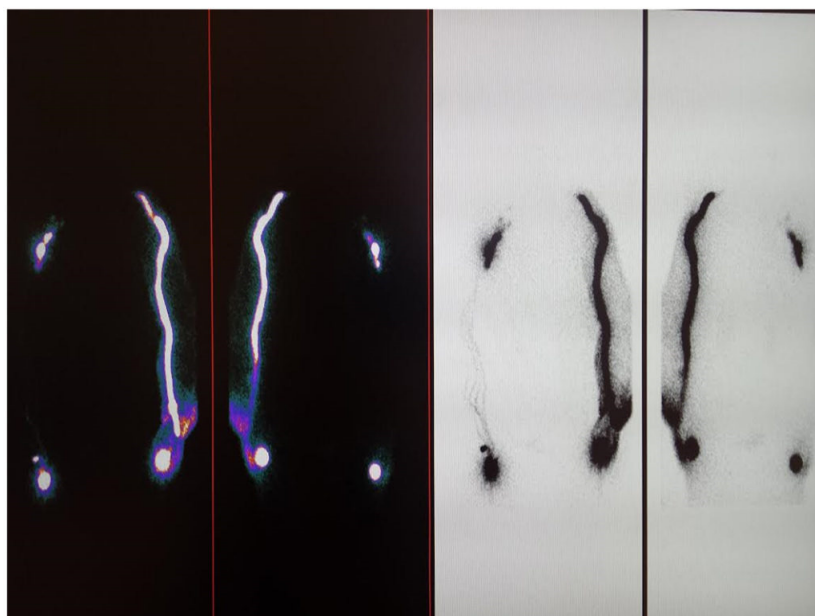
Lymphoscintigram of a female patients with left limb lymphedema after hysterectomy and radiotherapy because of uterine cancer. Tubings filled with isotope in the calf, thigh and outlet in the lumbar region.
